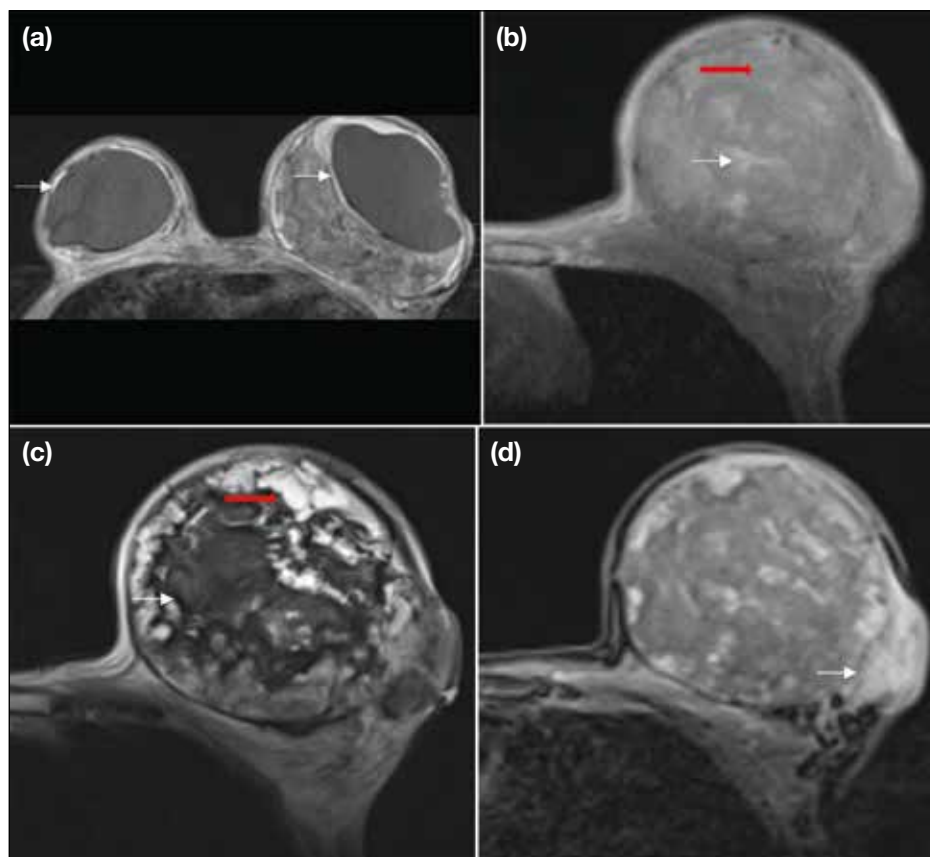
Angiosarcoma. (a) Magnetic resonance imaging of both breasts showing bilateral breast implants (thin arrows). Magnetic resonance images of the left breast. (b) T1-weighted, (c) T2-weighted, and (d) fat-saturated T1-weighted post-gadolinium sequences. An irregular, infiltrative solid mass is seen at the superolateral aspect of the left breast implant, showing peripheral contrast enhancement (thin arrow), particularly in the upper outer quadrant. Non-enhancing T1-weighted hyperintense and T2-weighted hypointense foci suggest tumoural haemorrhage (thin arrows), while non-enhancing T1-weighted hypointense and T2-weighted hyperintense foci are consistent with tumour necrosis (red arrows).
